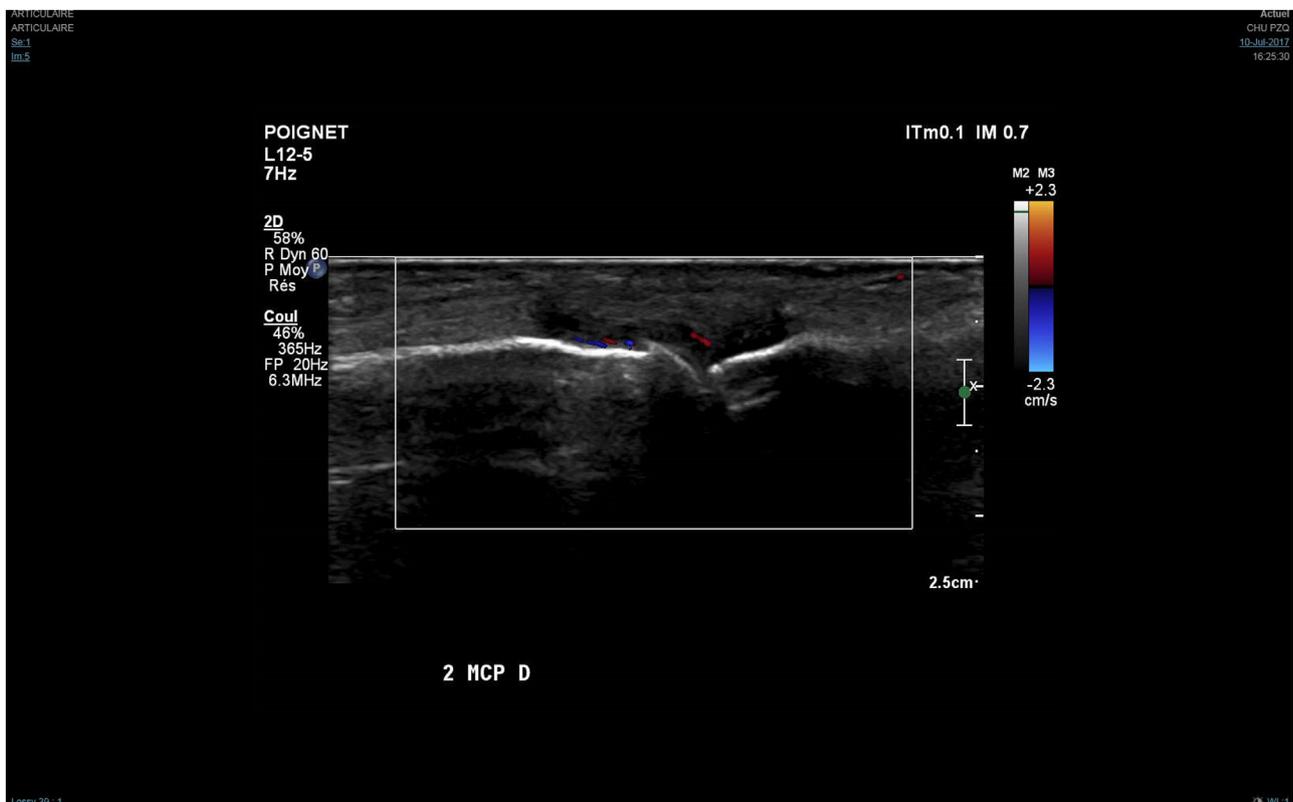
Doppler ultrasound examination of a second MCP. Presence of synovitis, with effusion and positive Doppler effect (grade 1, Szkudlarek' classification).
